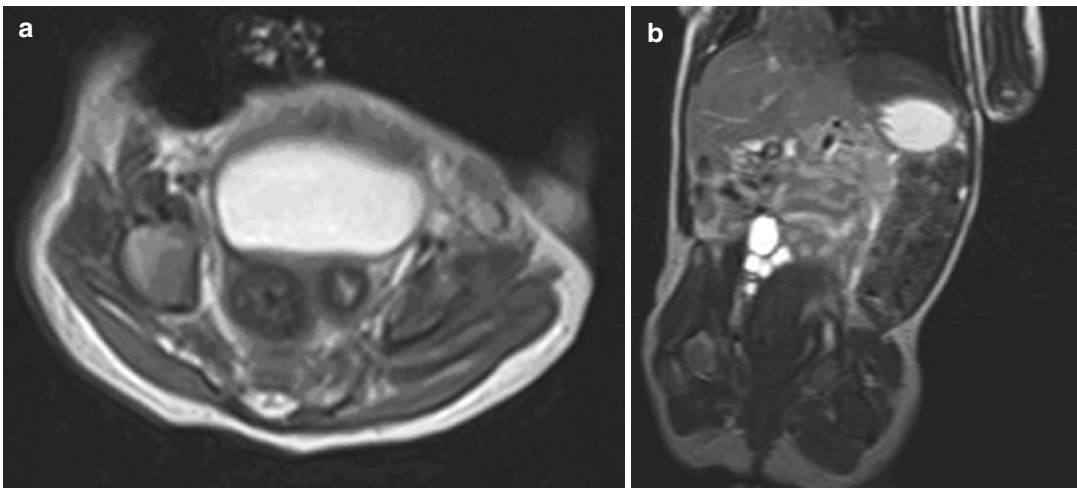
MRI: (a) Transverse T2 image, (b) Coronal T2—demonstrates uterus/endometrial cavity. (c) Sagittal T2 image showing normal anatomy, and (d) Transverse T2—inguinal gonads and uterus
